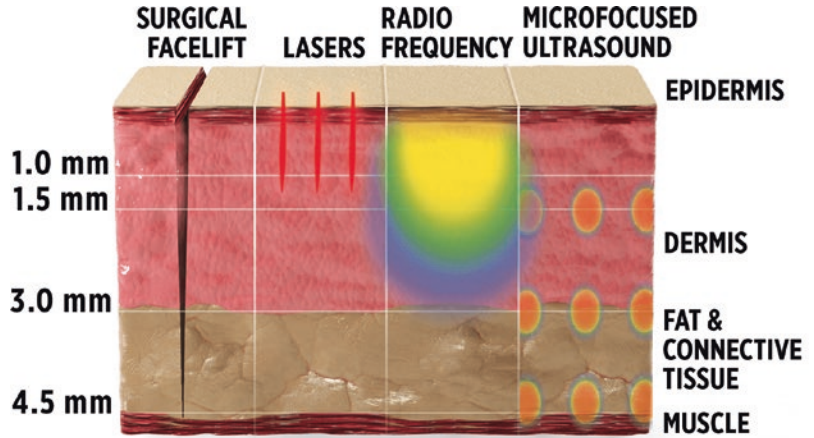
Green indicates depth of focused ultrasound energy to tissue
